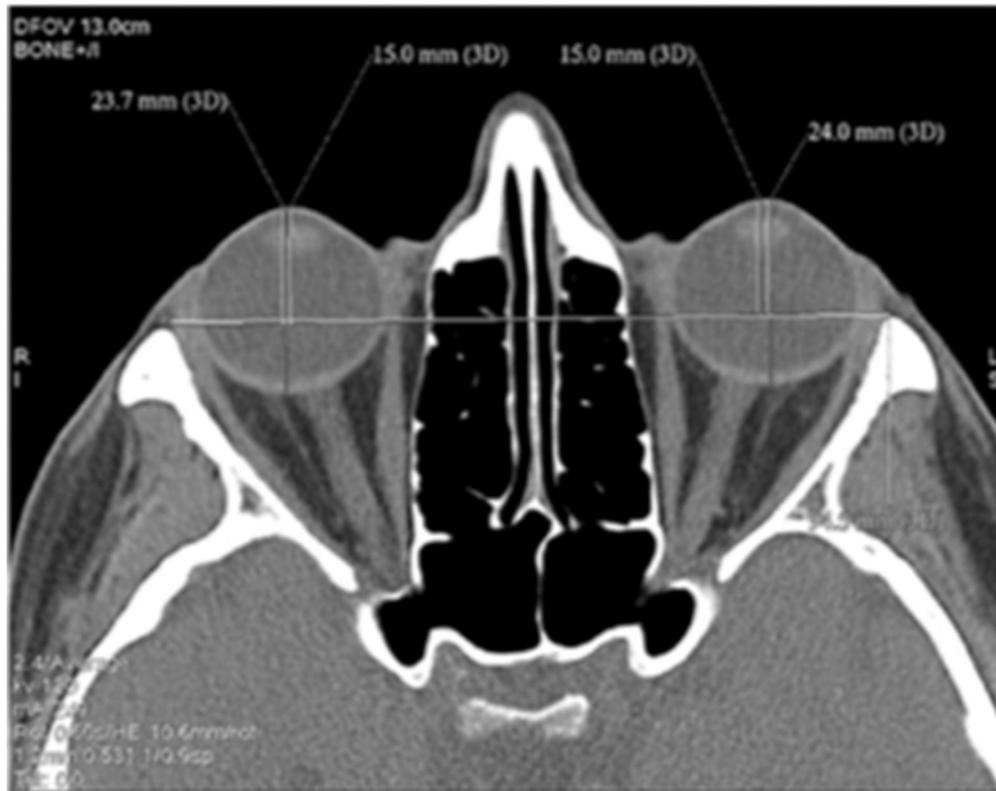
Measurement of proptosis by computed tomography, showing axial proptosis (in reference to the lateral orbital rims) of 23.7 mm in the right eye, and 24.0 mm in the left.¹⁸
